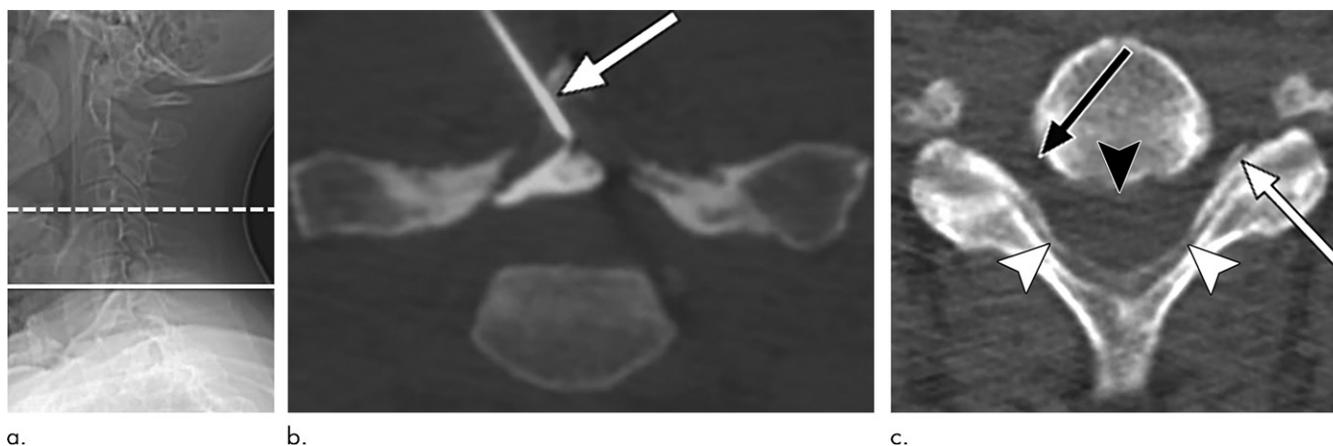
Axial CT images in a 47-year-old man with neck pain and left upper extremity radiculopathy. Cervical interlaminar epidural steroid injection was performed on the left in vertebrae C6/C7. (a) Preprocedural lateral scout image. Horizontal solid white line indicates level of injection in (b) and dashed white line indicates the level of image in (c). (b) Axial CT fluoroscopy image acquired during eccentric left needle (arrow) placement in vertebrae C6/C7. (c) Axial CT in vertebrae C4/C5 acquired during postprocedure imaging. Note the presence of contrast material within the bilateral dorsal epidural spaces (white arrowheads) and the ipsilateral neuroforamen (white arrow). Contrast agent is not present in the ventral epidural space (black arrowhead) or the contralateral neuroforamen (black arrow).
